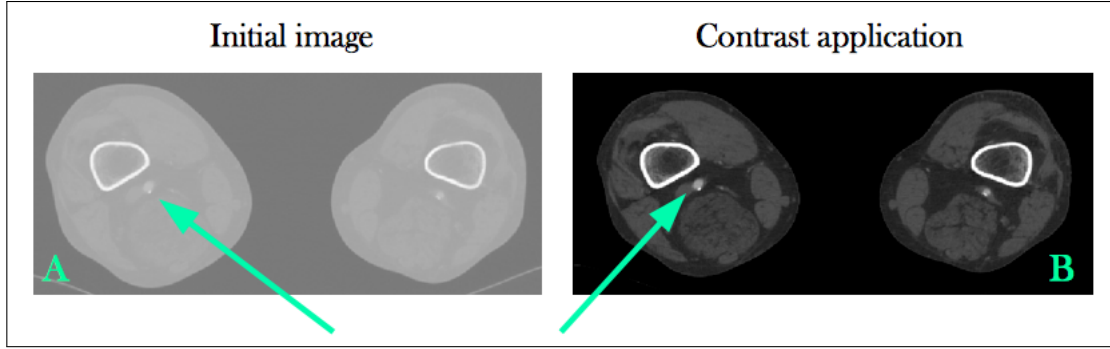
Comparison between a raw CT scan image (A) and the same image after the application of a simple intensity threshold filter (B).
